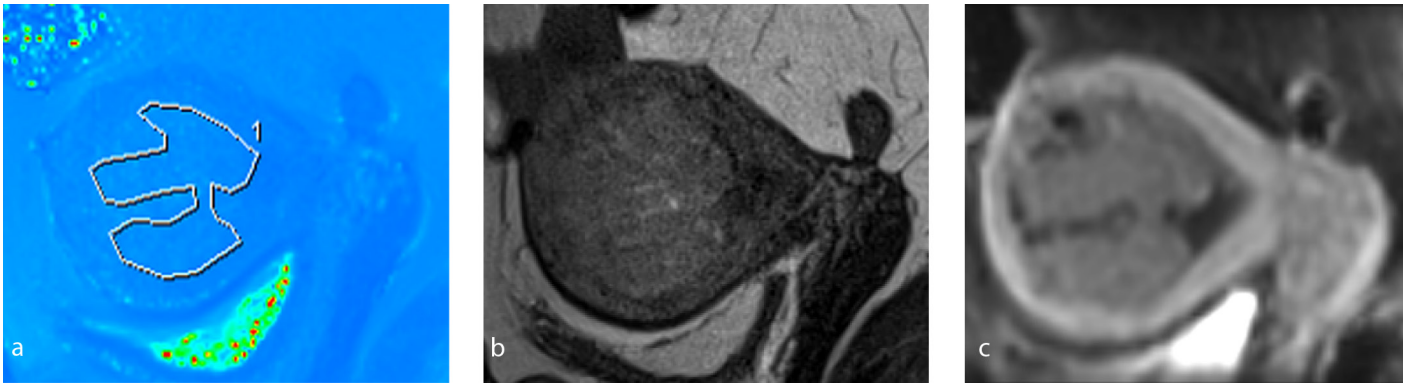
The ROI in a 65-year-old woman with type II endometrial cancer. (a) The ROI was manually placed in the lesions on the sagittal T2 map according to the morphology and size of the lesions to avoid the cystic and necrotic areas; (b) sagittal T2-weighted image and (c) sagittal enhanced image were used as the reference images. ROI, region of interest.
